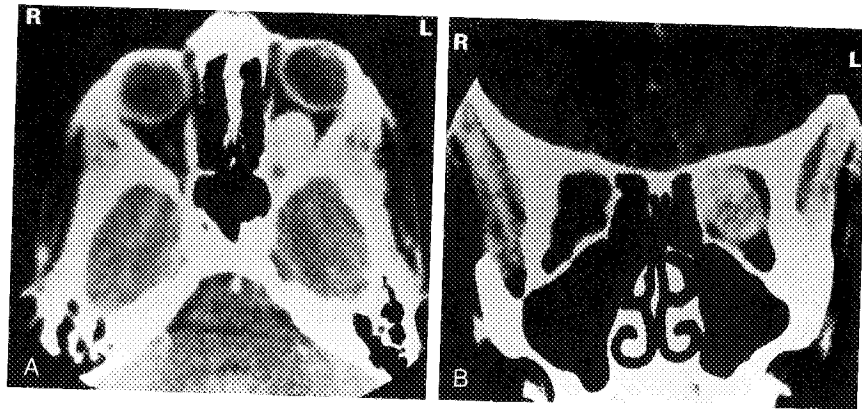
A and B, CT scan of an optic nerve glioma. Axial and coronal cuts demonstrate the fusiform enlargement of the optic nerve with a well-circumscribed homogeneous mass lesion.
